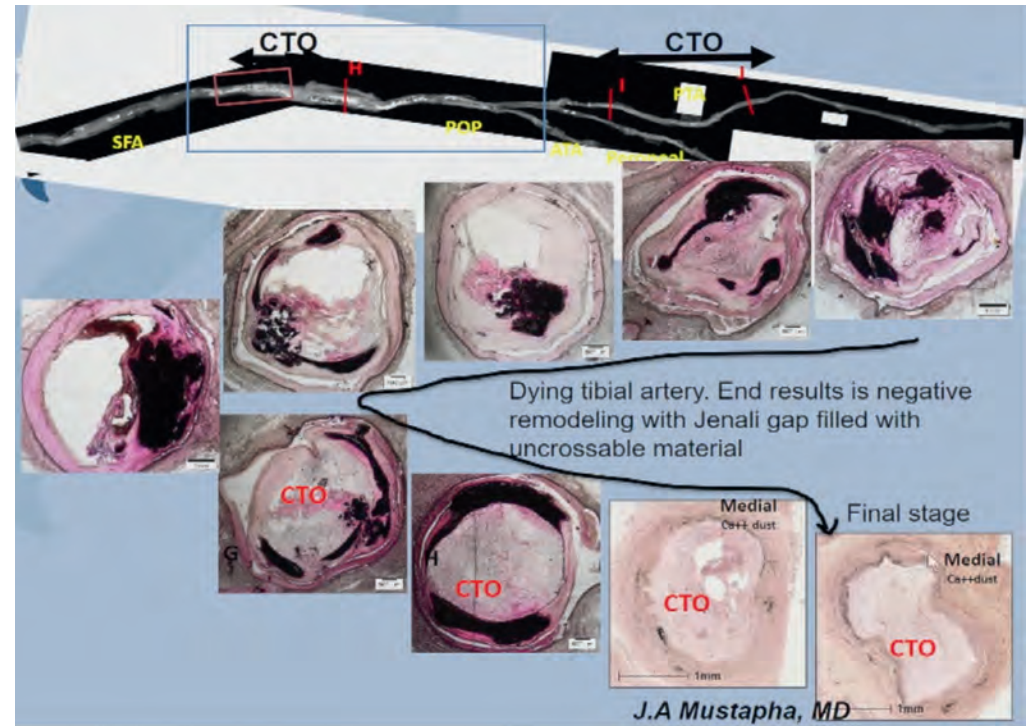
The evolution of tibial disease leading to formation of CTO. (Top right) Radiographic image indicates the Jenali gap, which is characteristic of negative remodelling. (Bottom right) At the culmination of CTO development, the intimal area is completely occupied by elastin fibres, surrounded by a purely calcific portion.
